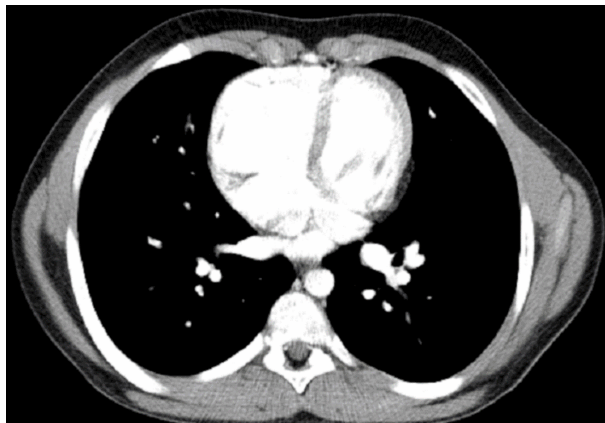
CT scan image showing dilated right heart with dilated coronary sinus in the same patient. CT: Computed tomography.
